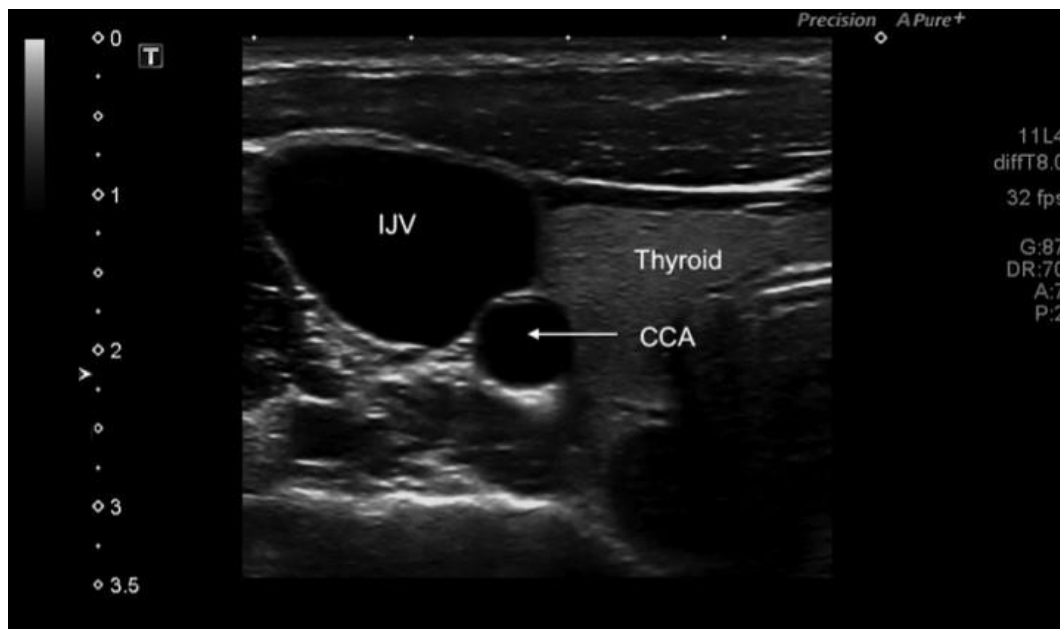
A typical brightness mode image visualising the carotid ultrasound in axial view.
